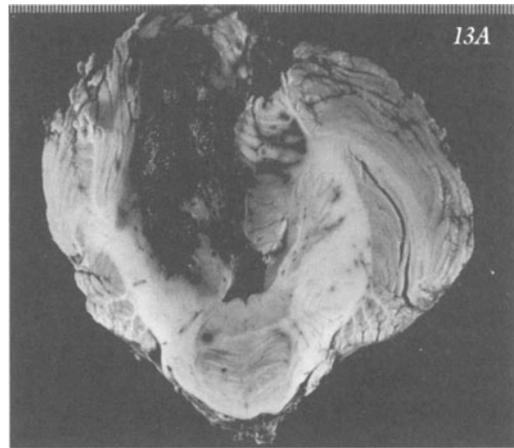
A) Large midline-paramedian cerebellar hemorrhage with rupture into the ventricle. This hypertensive (240/110) 61-year-old male had sudden onset of headache, vomiting, dizziness, ataxia of gait and trunk, nystagmus on left lateral gaze and minor incoordination of the left hand. (Courtesy of Dr. John Hills and Dr. Jose Segarra.) B) Large hypertensive hemorrhage into right cerebellar hemisphere with hydrocephalus. CT scan (non-enhanced). This 65-year-old white male who had hypertension, diabetes, congestive heart failure and alcoholism, developed over one hour, vomiting, and a marked ataxia of gait. Examination indicated severe ataxia of gait, marked horizontal nystagmus on gaze to the right, dysmetria on right finger-to-nose and heel-to-shin tests, plus a mild right Horner's syndrome and a mild dysarthria, and bilateral Babinski signs. Symptoms resolved over several weeks.
